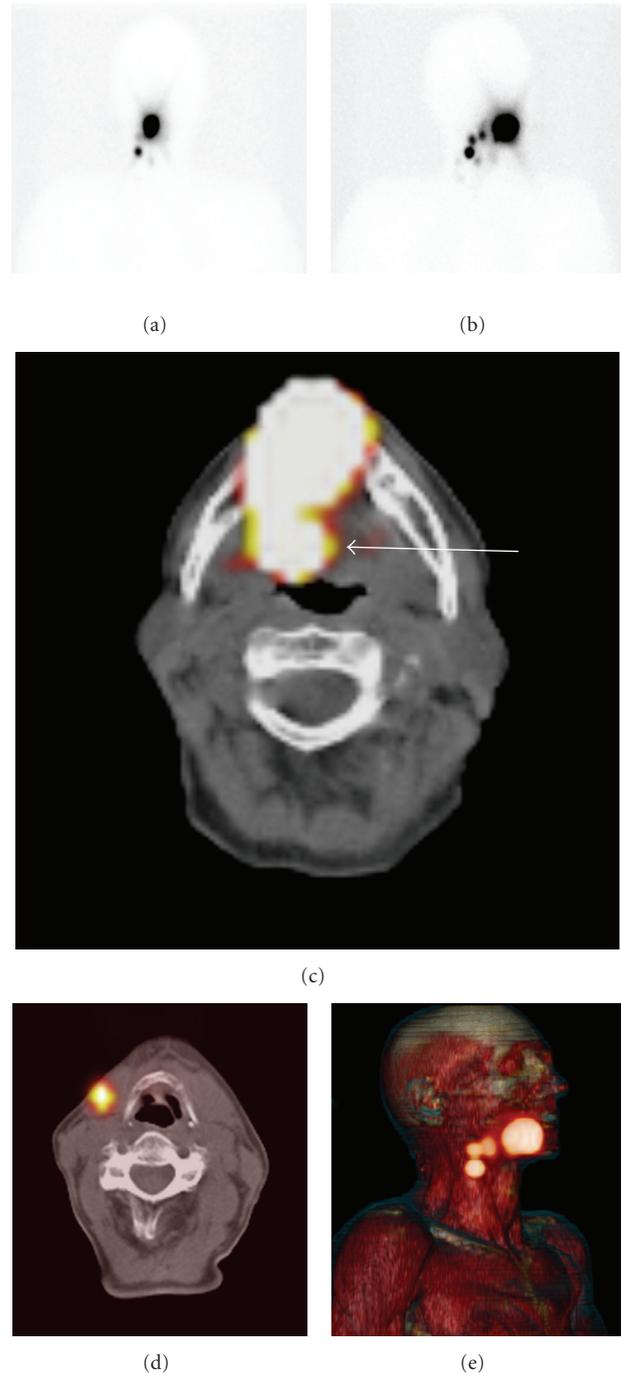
SPECT/CT to rule out a presumed sentinel node. Anterior (a) and oblique (b) planar static images after 2 hours show drainage to the right neck on the basis of which 3 sentinel nodes were marked. SPECT/CT (c) demonstrates the cranial hotspot located at the base of the tongue in the oropharynx (arrow), due to leakage of the tracer from the injection area. The sentinel nodes are clearly visualized with SPECT/CT (d), while three-dimensional reconstruction (e) shows an anatomic overview of all hotspots.
